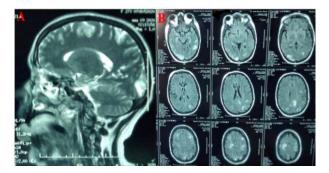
(A-B): A brain MRI scan showed multifocal, T2-hyperintense lesions symmetrically surrounding the white matter of the temporoparietal and occipital regions and the left frontal lobe.
